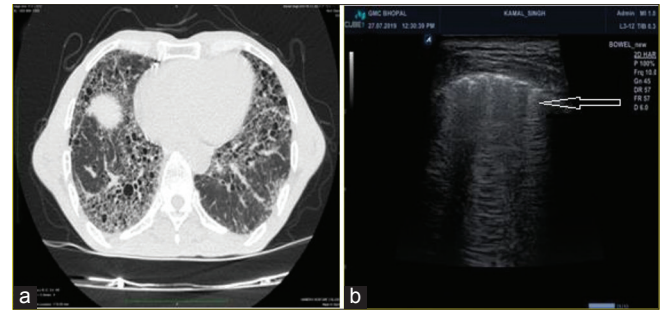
(a) High resolution computed tomography of the chest showing bilateral subpleural reticular and honeycomb shadows in a patient. (b) Transthoracic sonography shows B lines (white arrow) arising from the pleural line with a distance between the two B lines of about 7 mm
